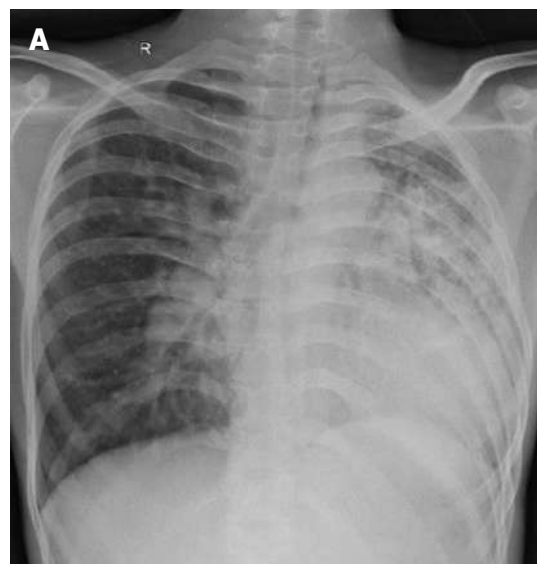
A) Chest X-Ray Before and B) After 2 Months TB Treatment
